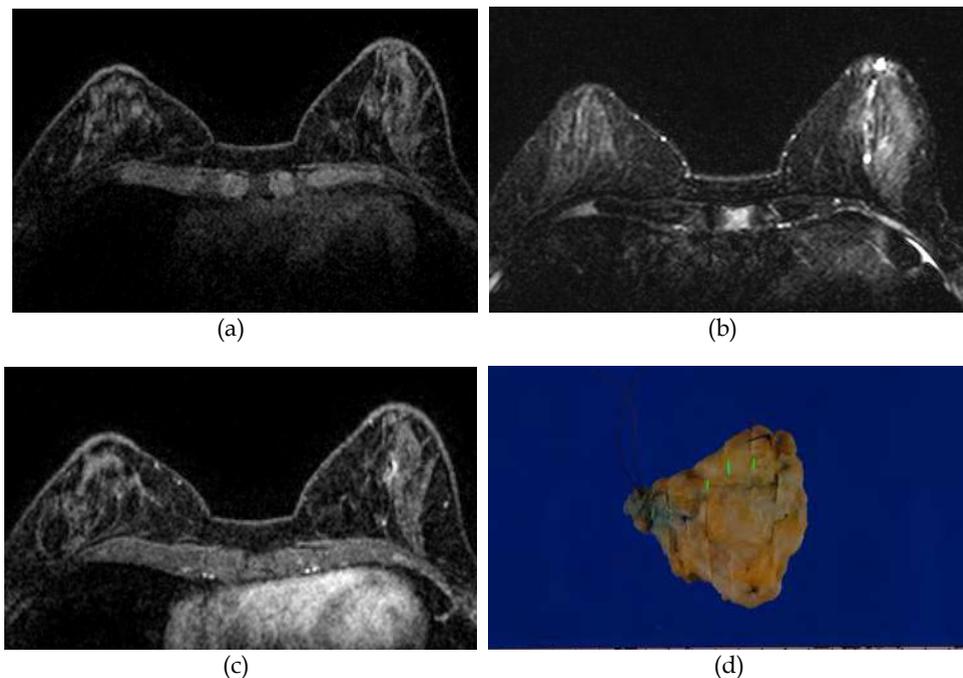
Images of the breasts of a 49-year-old woman who presented with bloody discharge from the left nipple. (a) Pre-contrast fat-suppressed T1-weighted MR image showing no intraductal abnormal intensity. (b) STIR MR image showing duct ectasia and intraductal fluid accumulation. (c) A contrast-enhanced T1-weighted MR image showing homogeneous ductal enhancement. (d) Mapping of the lesion (green line area, intraductal papilloma.).
